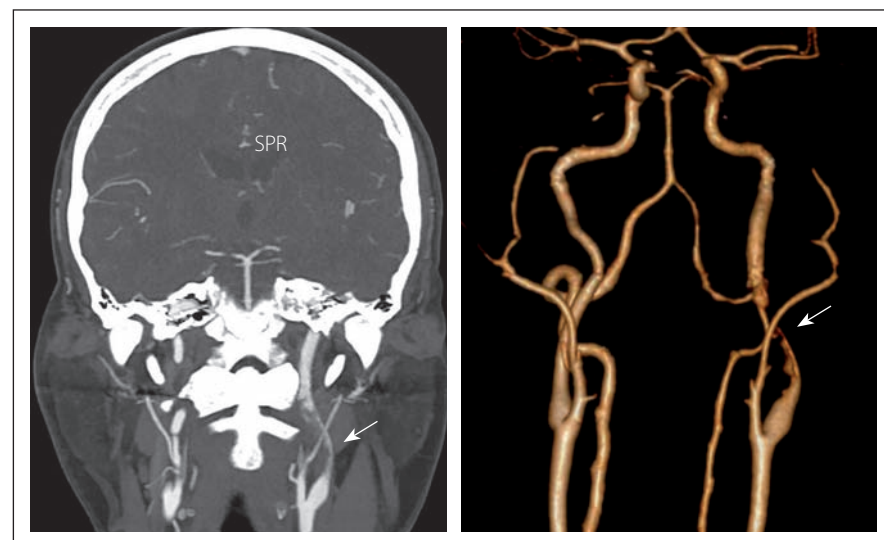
CTA in coronal section (left) and 3D reconstruction (right) shows intraluminal filling defect in the extracranial segment (C1) of the left internal carotid artery of 3 cm in length (arrow).
